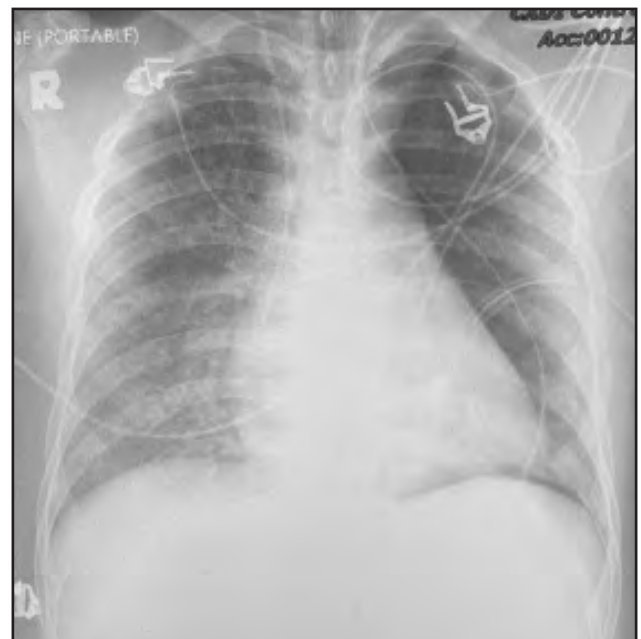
Chest X-ray on day 7 of ICU admission
